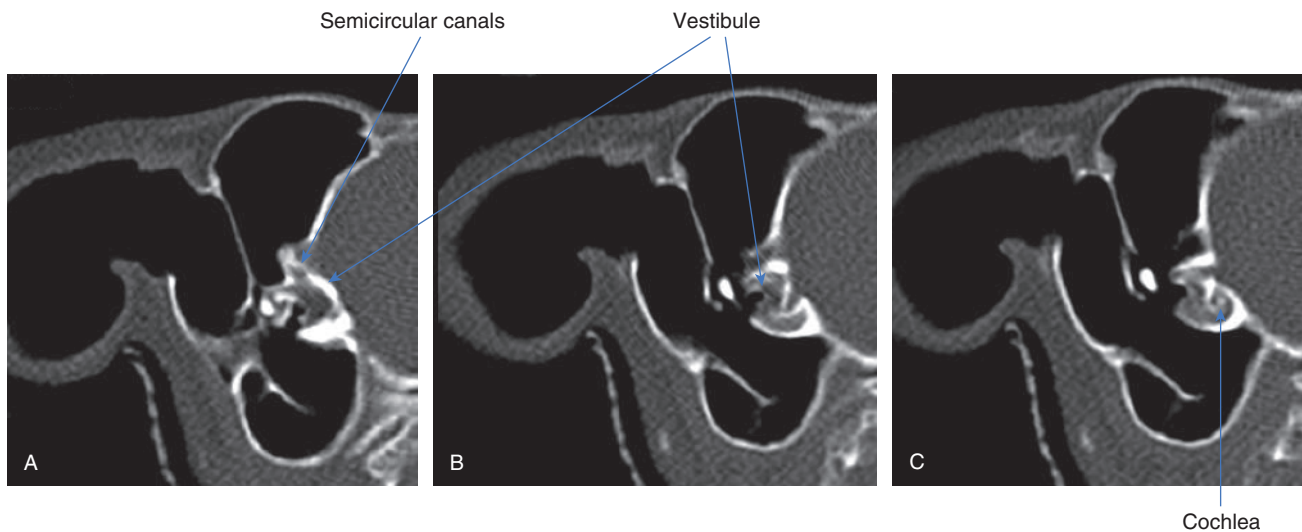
CT series of the right inner ear of a chinchilla, moving from caudal to rostral. The semicircular canals (A), vestibule (B), and cochlea (C) are easily detectable on CT in this species. (Courtesy, UTCVM Radiology) © 2012 The University of Tennessee.
